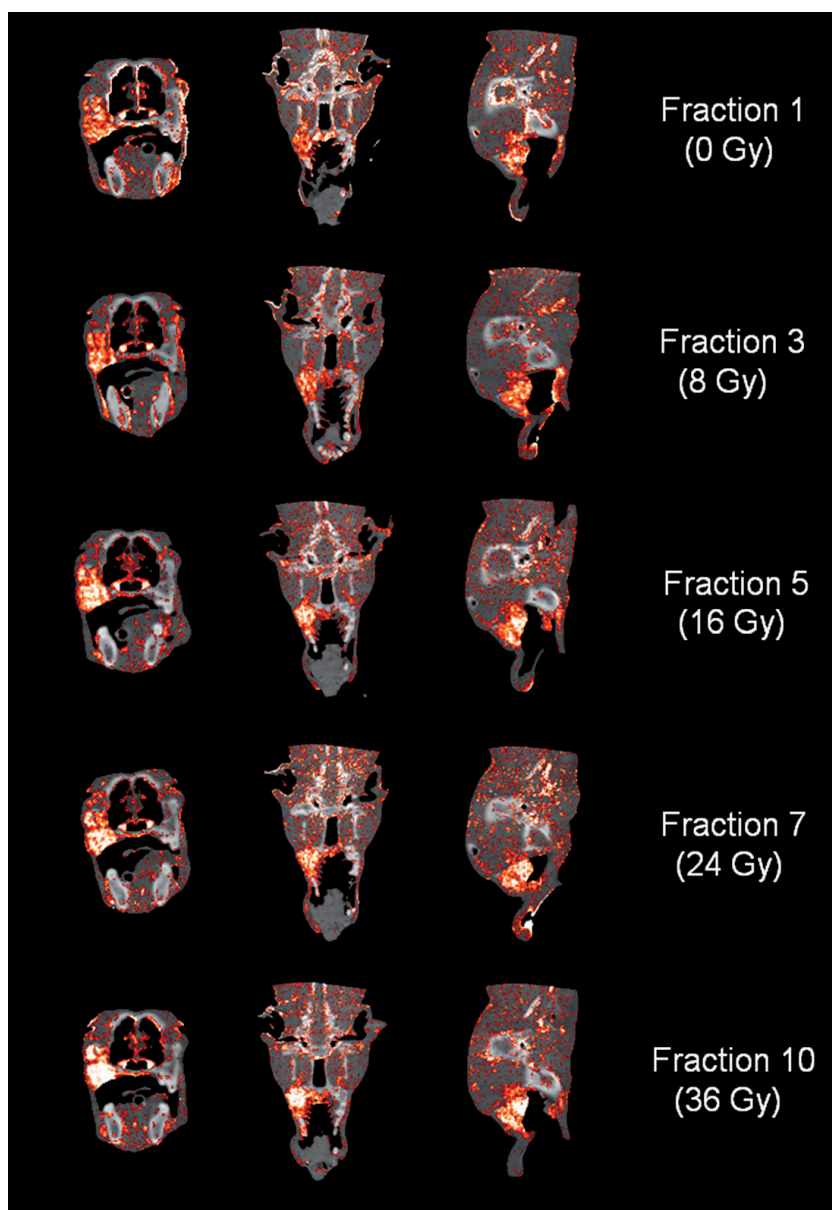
Reconstructed CBCT images in three planes with contrast enhancement overlay at five treatment fractions. High uptake/enhancement is indicated by bright colours.
